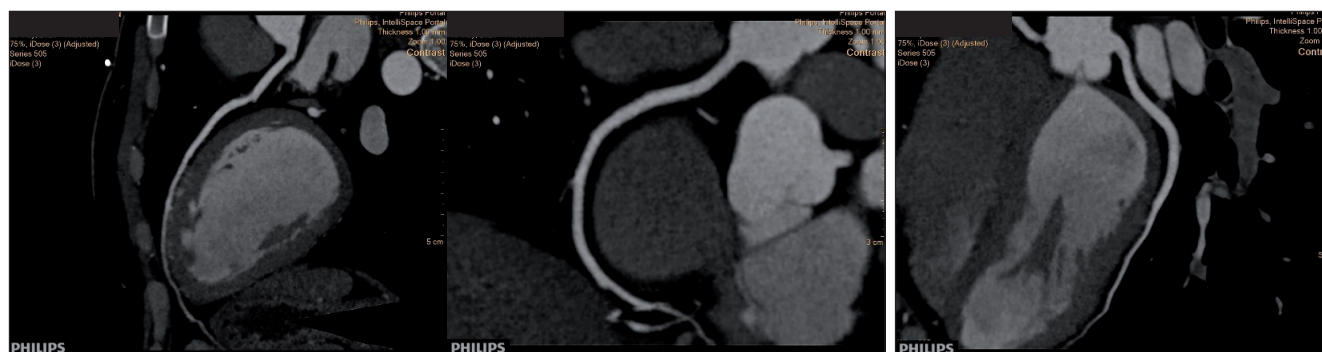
CT angiography shows normal coronary arteries.
